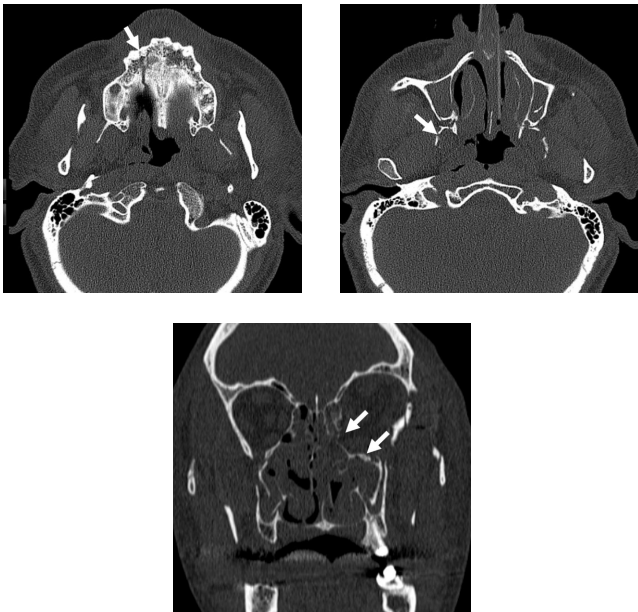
In a 50-year-old male patient, fractures in the anterior, lateral, and base of the right maxillary bone (a), pterygoid bones, and the base of the right maxillary bone in the axial (a, b) and coronal (c) unenhanced maxillofacial CT scans (arrows).
